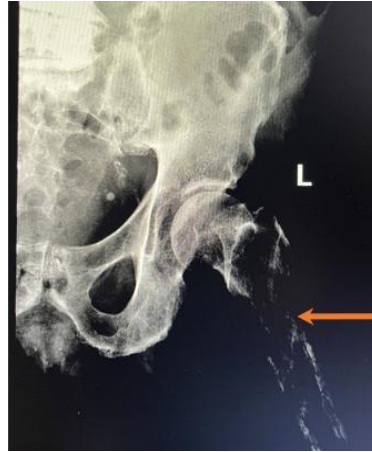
Radiograph of the left femur showing permeative destruction of the left lesser trochanter and the proximal femoral shaft.
